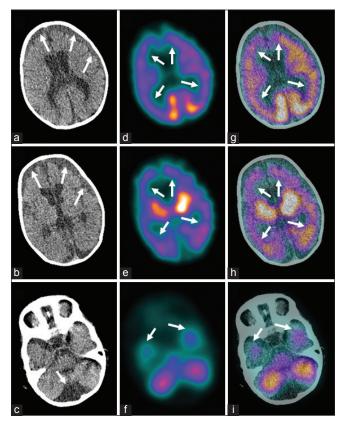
Transaxial <sup>99m</sup>Tc-ehylene cysteine dimer (<sup>99m</sup>Tc-ECD) hybrid Single photon emission tomography/computed tomography (SPECT/CT) images. The non-contrast transaxial CT images (a-c) confirms the subdural hygroma (arrows) seen on MRI. Transaxial SPECT (d-f) and SPECT-CT (g-i) images demonstrates hypoperfusion involving bilateral frontal, parietal, and temporal cortices (arrows). Contrary to the subdural hygroma, the hypoperfusion is more marked on the right side. The occipital cortex and the cerebellum show preserved perfusion, while the basal ganglia demonstrate relative hyperperfusion, more marked on the left (e)
